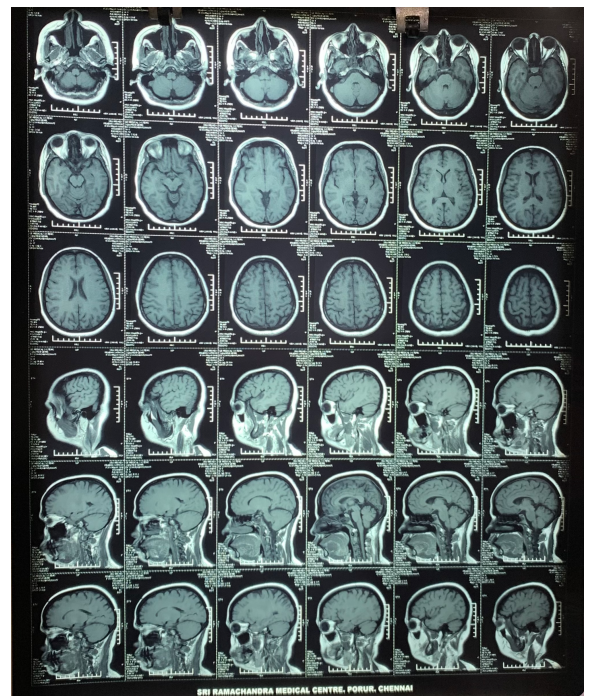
MRI Brain — T1-weighted axial and sagittal sequences demonstrating normal cerebral parenchyma with preserved cortical gyri and sulci. No
